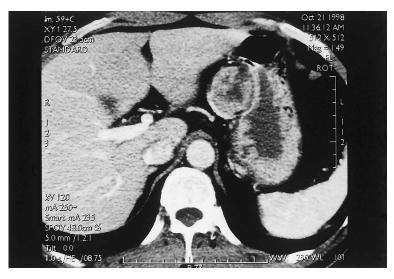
Contrast-enhanced CT scan findings were similar to those of ultrasonography.
